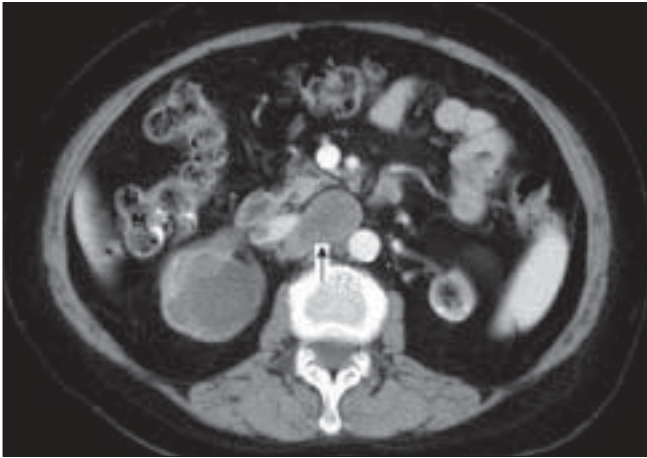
Contrast-enhanced CT scans: Right renal mass (CT value 42 HU) with slight enhancement (CT value 55 HU) on contrast enhancement, right hydronephrosis; multiple enlarged abdominal lymph nodes (with arrow head); and left shrunken kidney
